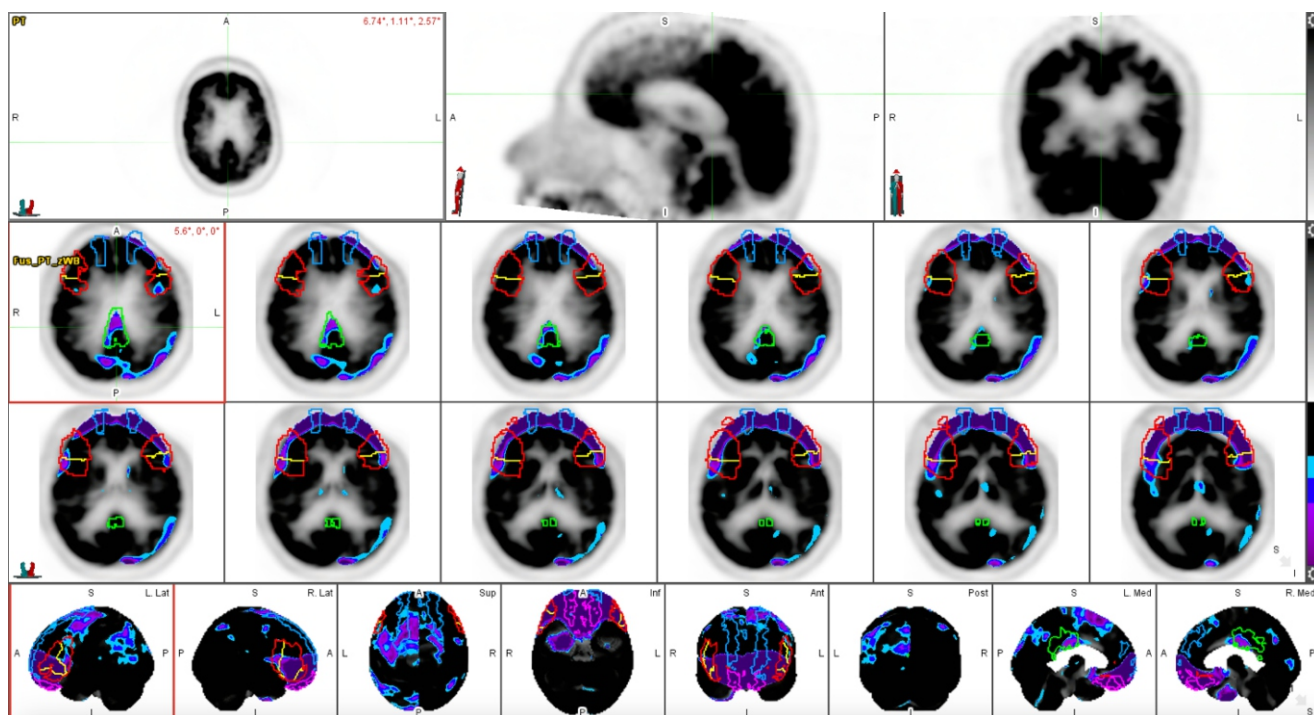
Evaluation of ^{18}F -FDG PET through quantitative analysis using MIMneuro version 7.1.5 (MIM Software, Inc., Cleveland, OH, USA). Low ^{18}F -FDG uptake is represented by purple and blue contours. The medial orbital gyrus (pink), and inferior frontal gyrus (red), inferior frontal gyrus, pars orbitalis (light blue), inferior frontal gyrus, pars triangularis (yellow), superior frontal gyrus (blue), and posterior cingulate gyrus (green) have been delineated as regions of interest in this patient.
